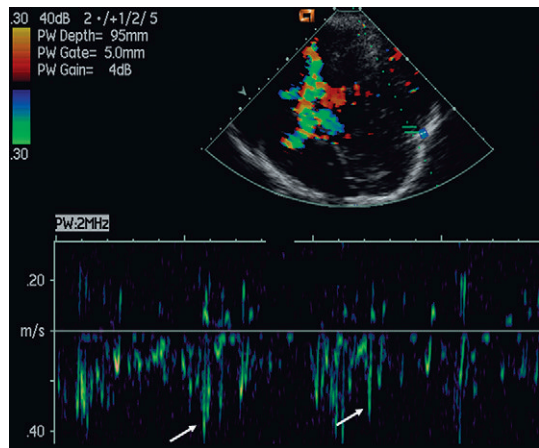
Sharp spikes of Doppler 'noise' (arrows) are seen in the spectral Doppler trace obtained from a transcranial ultrasound examination following the administration of Levovist®, arising from collapse of the microbubbles or aggregation of microbubbles.
